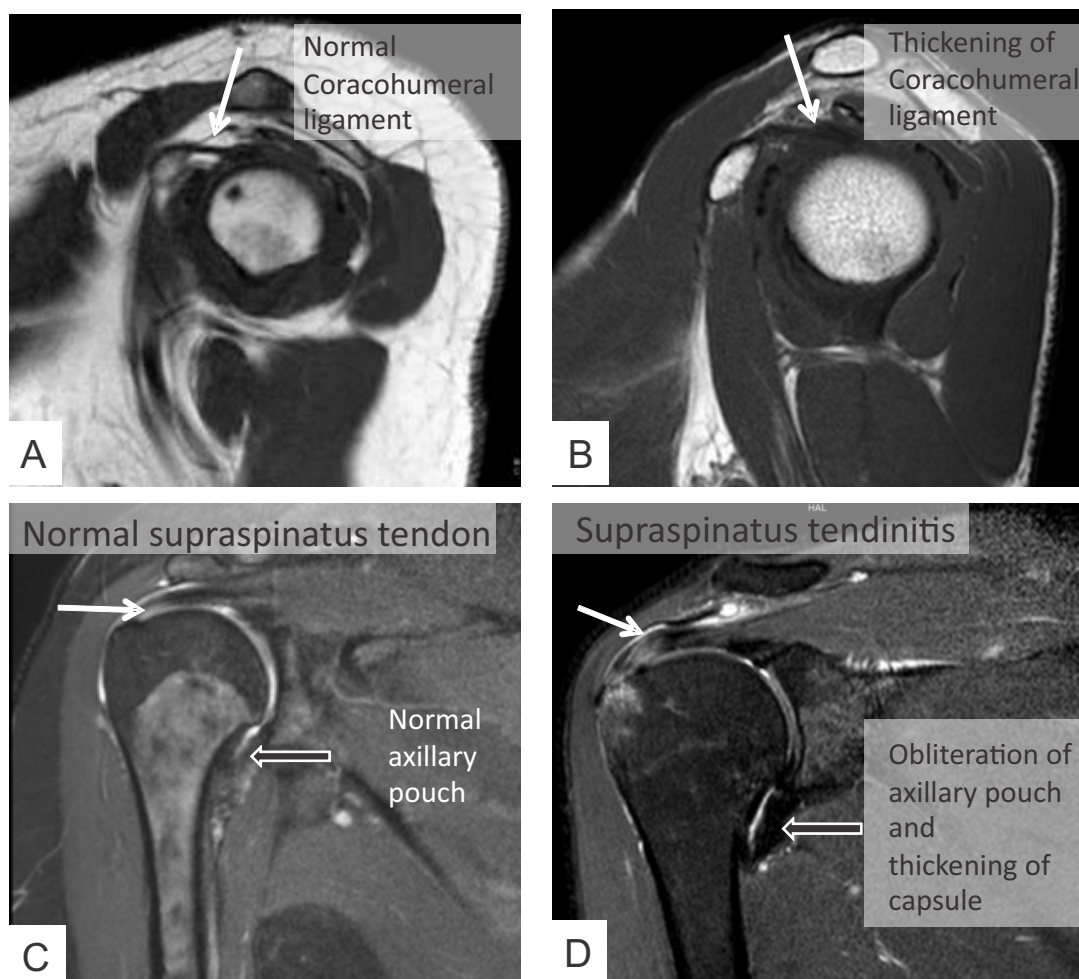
T1 weighted MR images (A, B) in sagittal oblique plane showing normal appearance of coracohumeral ligament (arrow in image A) and abnormally thickened coracohumeral ligament with surrounding fat stranding (arrow in image B). T2 weighted fat suppressed images (C, D) in coronal oblique plane showing normal axillary pouch (black arrow in image C) and thickening of capsule with obliteration of axillary pouch (black arrow in image D). There is supraspinatus tendinitis with associated marrow edema also seen (white arrow in image D).
